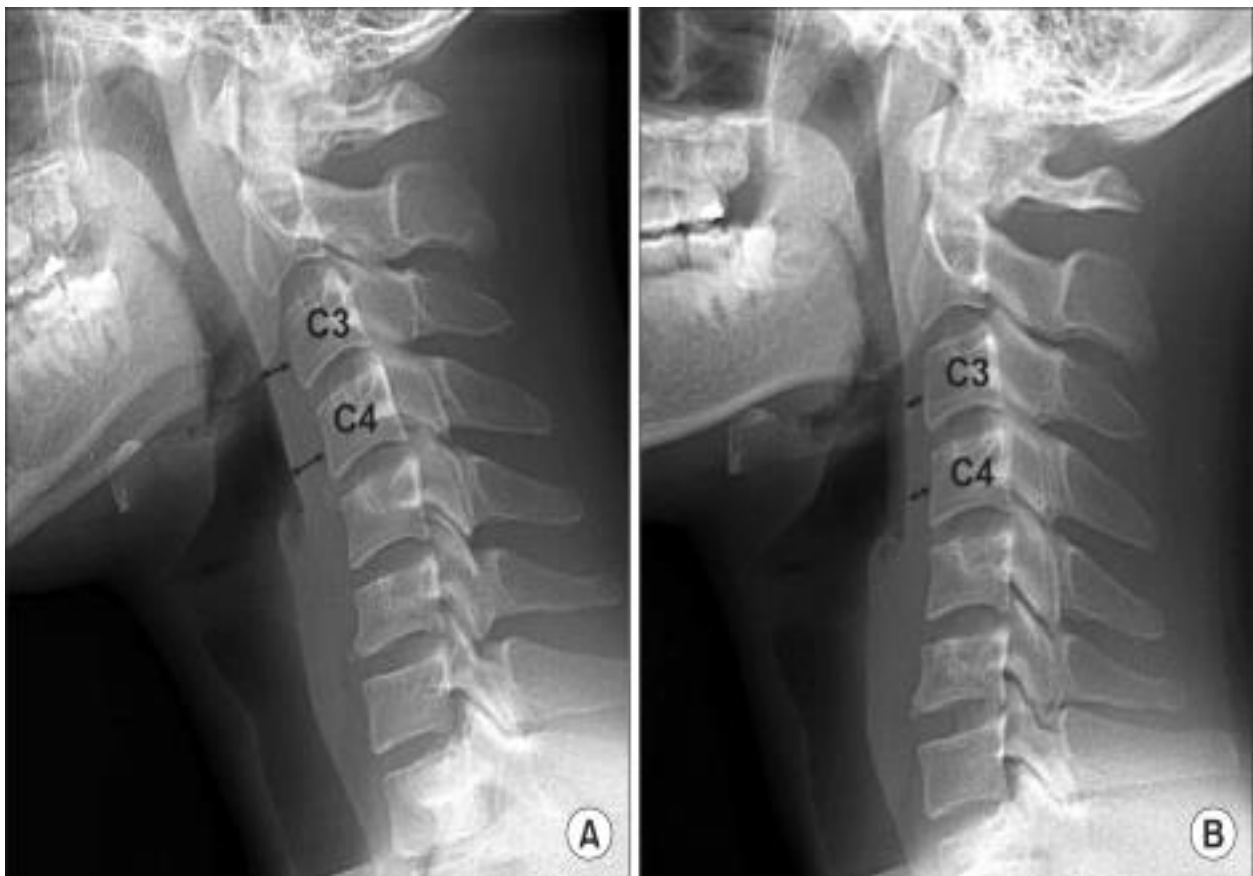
(A) Initial lateral cervical spine radiograph shows increased thickness of prevertebral soft tissue: 8 mm at C3 and 10.5 mm at C4. (B) At the 5-day follow-up point, lateral cervical spine radiograph shows a normalization of shadow of prevertebral space: 4.5 mm at C3 and 6 mm at C4. ⁽²³⁾
